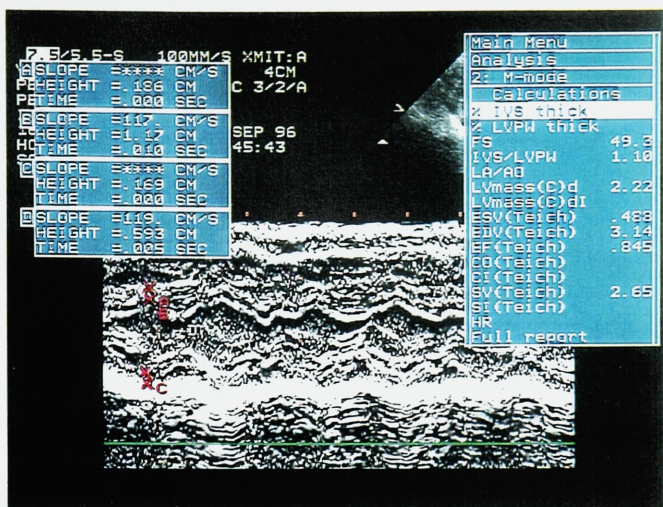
This is a representative M-mode echocardiogram from a subject at enrollment, where A marks the thickness of the interventricular septum, B marks the dimensions of the left ventricle, and C represents the thickness of the left ventricular posterior wall. In this patient the interventricular septum measures 0.186 cm and the left ventricular posterior wall measures 0.169 cm, with a normal IVS/LVPW of 1.10.
